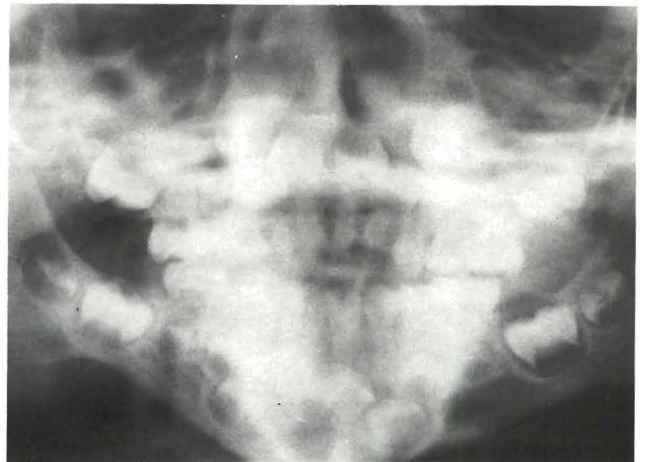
Panoramic radiograph showing condylar hypoplasia on the right with mandibular asymmetry and fusion of the left mandibular central and lateral incisors.
